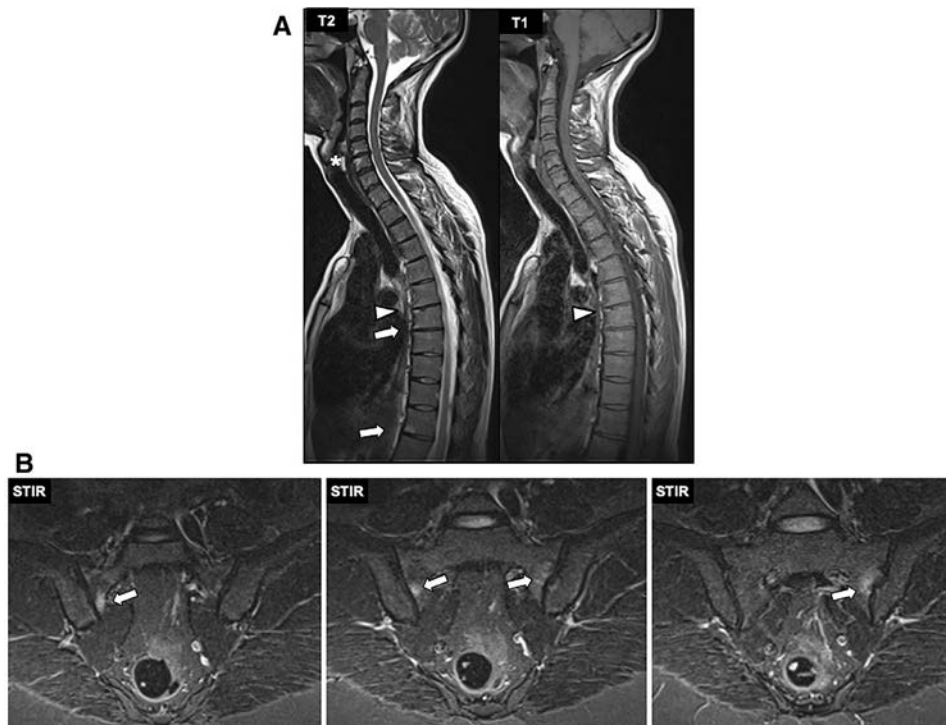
(A) Example of hyperintense signals in the T2-weighted and T1-weighted spinal MRI sequences of a male patient, age 39 years. *Arrowhead*: Fatty lesion at the edge of a thoracic vertebra, seen as hyperintense signal in both T2-weighted and T1-weighted MRI sequences. *Arrows*: Bone marrow oedema at the edge of a thoracic vertebra, seen as hyperintense signal only in the T2-weighted MRI sequence. *: Example of a lesion that was not counted as positive despite hyperintense signal on the T2-weighted sequence, due to the concomitant dehydration of the adjacent intervertebral disk and the small protrusion in this segment. (B) Example of hyperintense signals in the STIR MRI sequences of the SIJ of a female patient, age 41 years. *Arrows*: Bone marrow oedema seen as periarticularly located hyperintense signal on STIR MRI. SIJ, sacroiliac joints; STIR, short tau inversion recovery.
